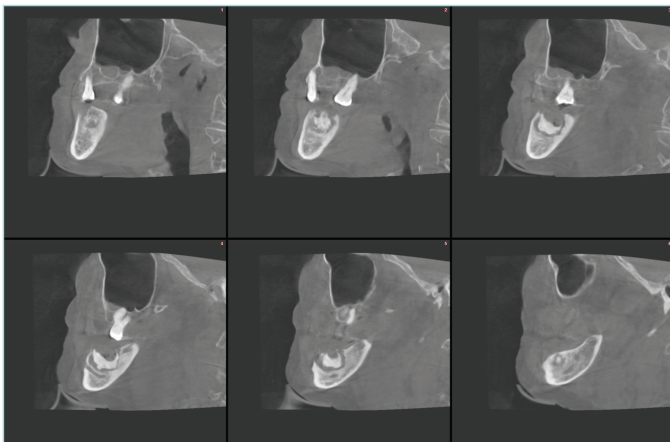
Sagittal view of the case in CBCT.
